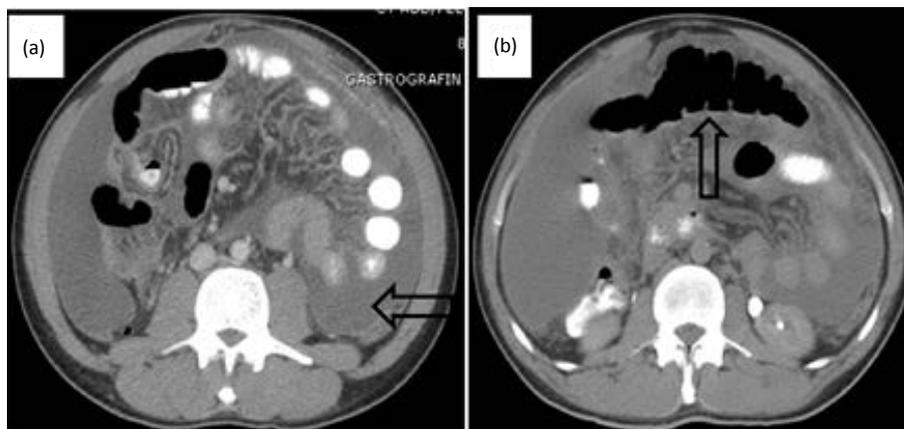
Computed Tomography of the abdomen. (a) CT scan shows large ascites (arrow) which displaces the small intestines and mesentery. (b) Probable inflammatory changes in the omentum (arrow) and in the mesentery of the rectosigmoid colon. Minimal bibasilar atelectasis, small left pleural effusion and small left cardiophrenic angle adenopathy are also present.
